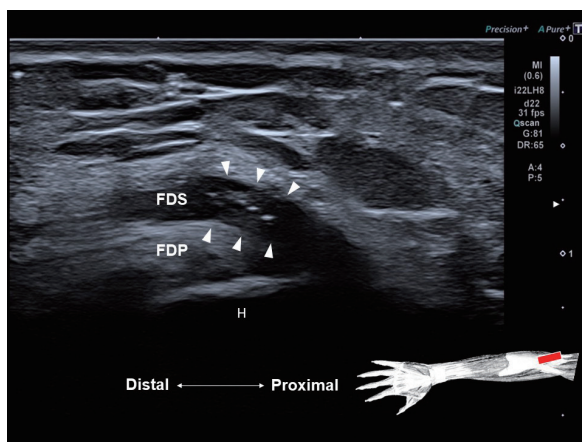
Long-Axis Ultrasound Image of the Common Flexor Tendon Demonstrating a Tear of the Flexor Digitorum Superficialis Tendon (White Arrowheads), Characterized by Focal Tendon Thickening and Loss of the Normal Fibrillar Architecture
